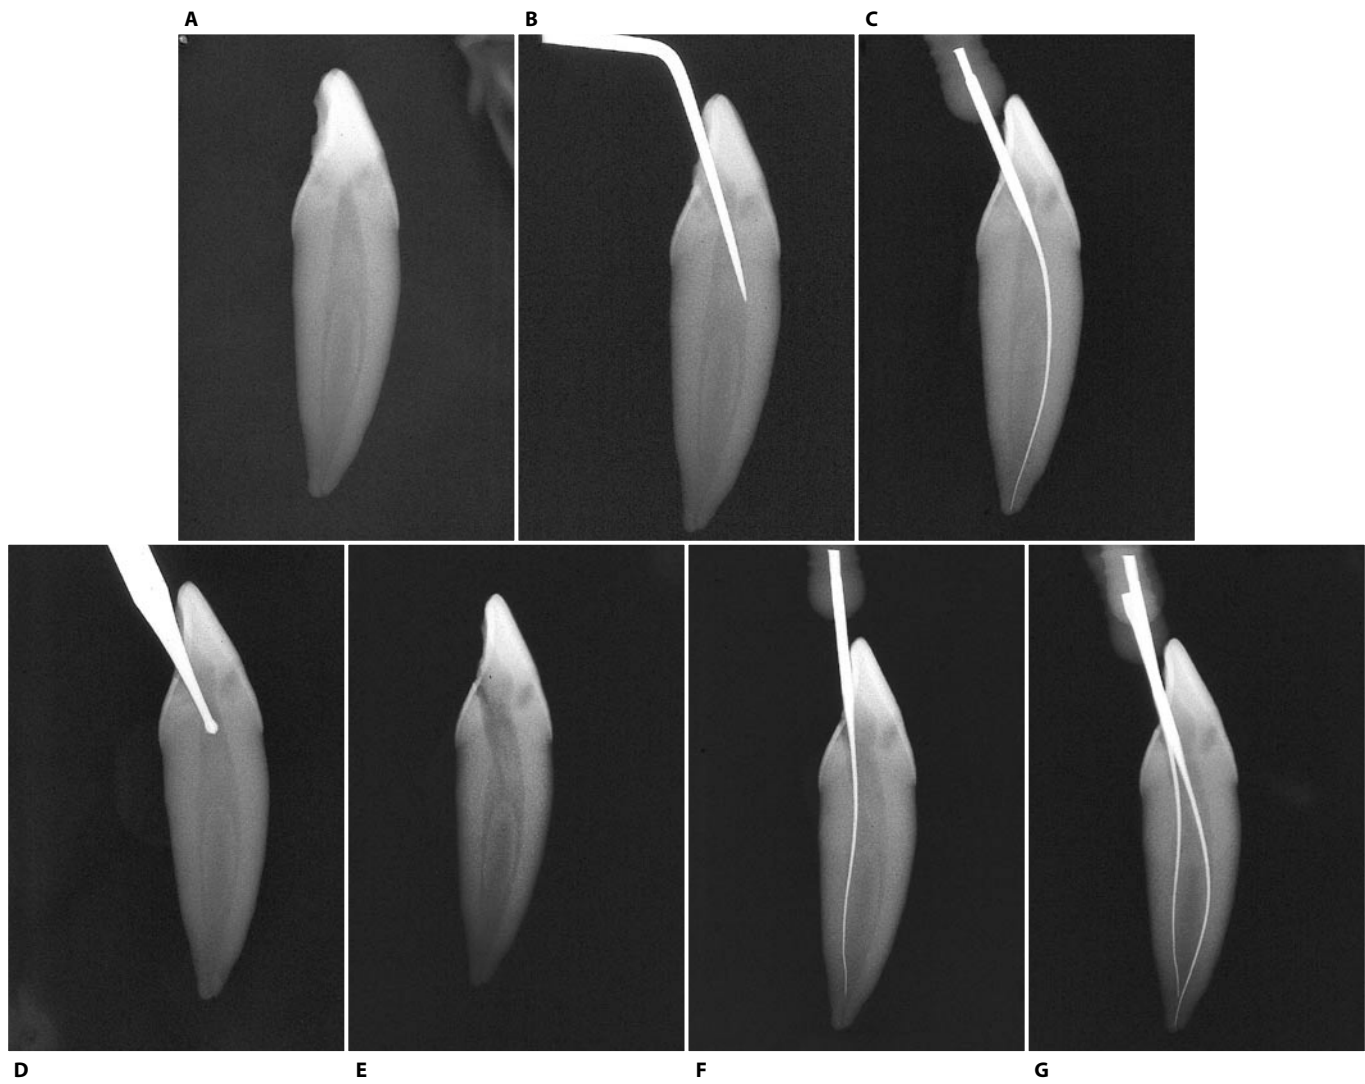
A. Radiographic appearance of the lower central incisor in a mesiodistal projection. B. A limited access cavity has been created. C. A # 08 file enters the buccal canal, though with considerable coronal interference. The presence of "triangle # 2" impedes the entrance of any instrument into the lingual canal. D. The low-speed round bur completely excises the dentinal triangle. E. Radiographic appearance of the completed access cavity. F. The # 08 file can now enter the lingual canal easily. G. The two instruments confirm the presence of two canals with a common apex.
